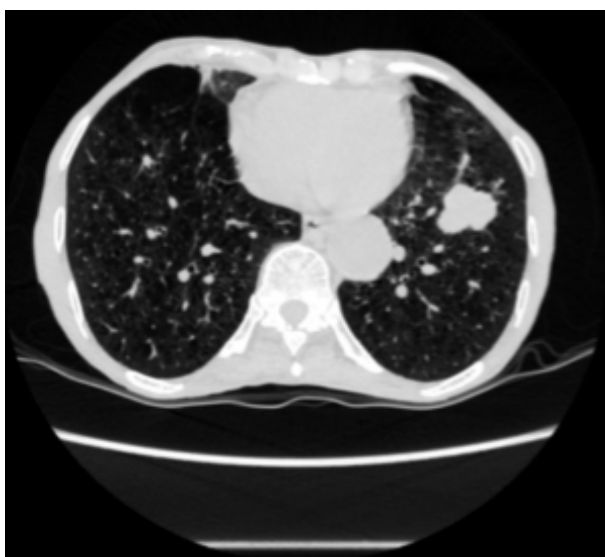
Axial CT of thorax showing a mass with lobulated margins in left upper lobe
